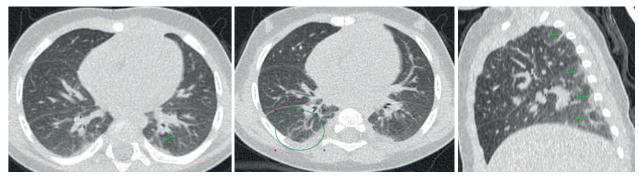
Patient U.M. Computed tomography performed 6 months after discharge. Imaging data suggestive of bilateral diffuse pneumofibrotic changes
